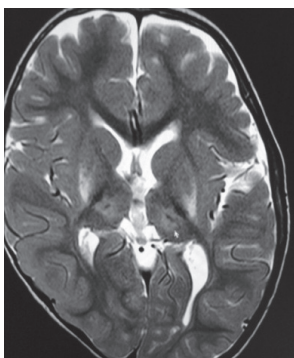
MRI brain shows T2 hyperintensities at bilateral putamen and bilateral thalami
